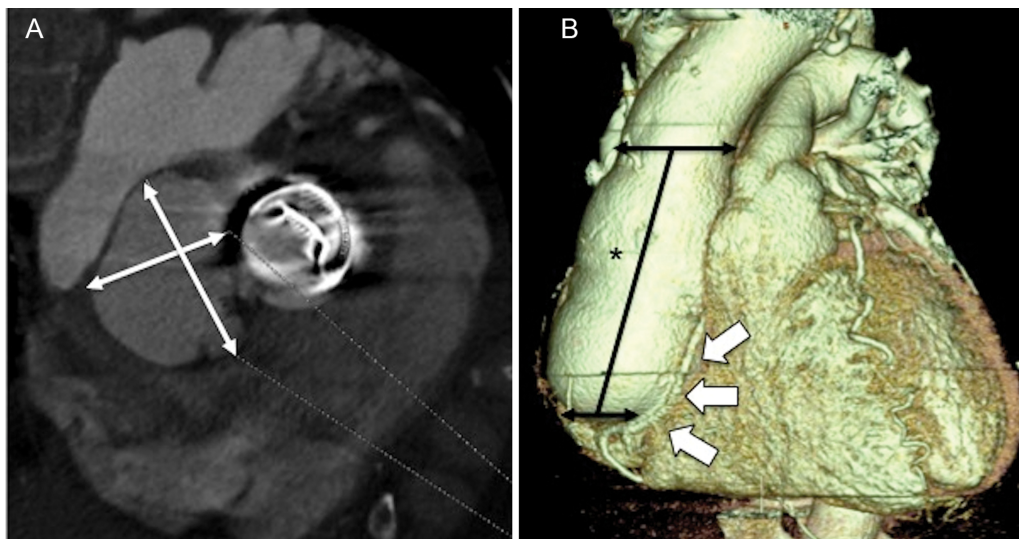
(A) Computed tomography shows the pseudoaneurysm arising from the aortic sinus (3×4 cm). At the annular level in the aortic position is a perfectly functioning Björk–Shiley prosthesis (dp mean 6 mmHg transvalvular). (B) 3D computed tomography demonstrating the aneurysm at its longest axis of 7.9 cm (asterisk). Arrows mark the course of the distal right coronary artery, which can be seen between the aneurysm and the right outflow tract.
